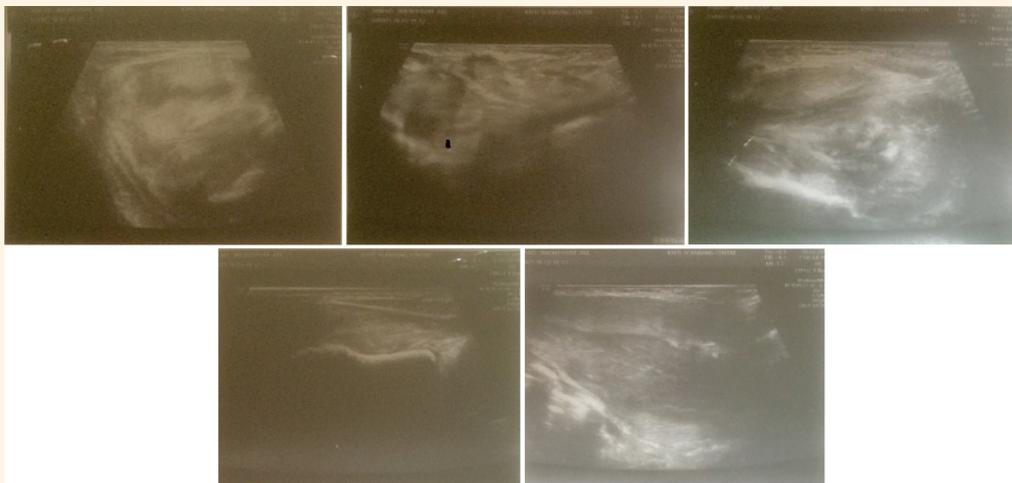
Ultrasonography of the right shoulder of a three-month-old male infant showing relatively bulky adjacent muscles around the scapula with altered echogenicity without any evidence of fluid collections.
